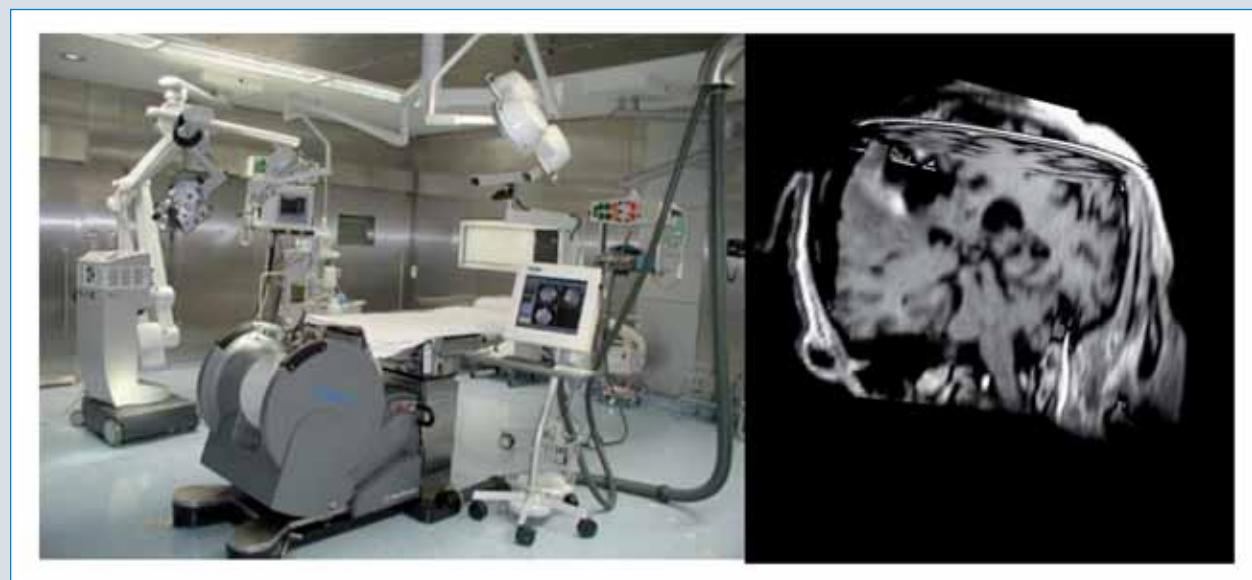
Intraoperative MRI coupled with image-guidance system (left) and acquired image showing the extent of a lesion resection (right)
